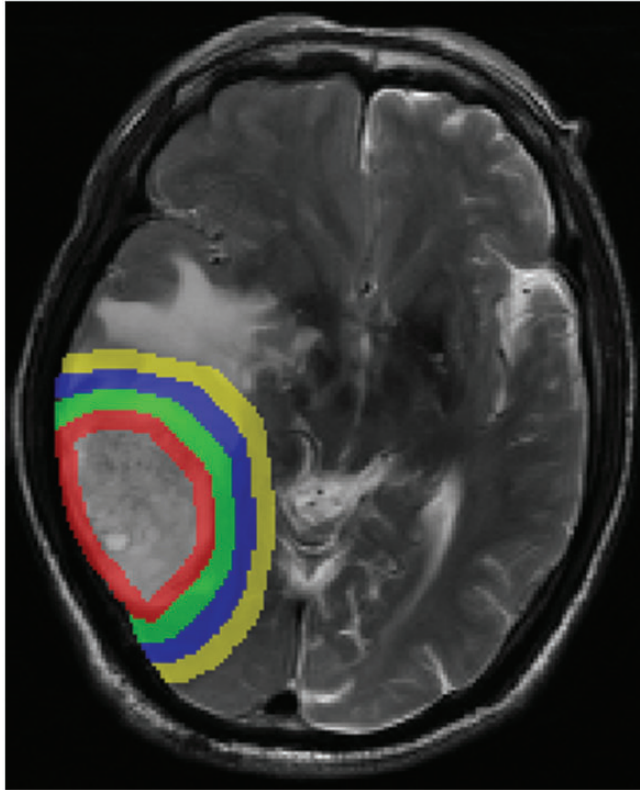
Representative brain magnetic resonance image of the peritumoral areas (5/10/15/20 mm, respectively).
